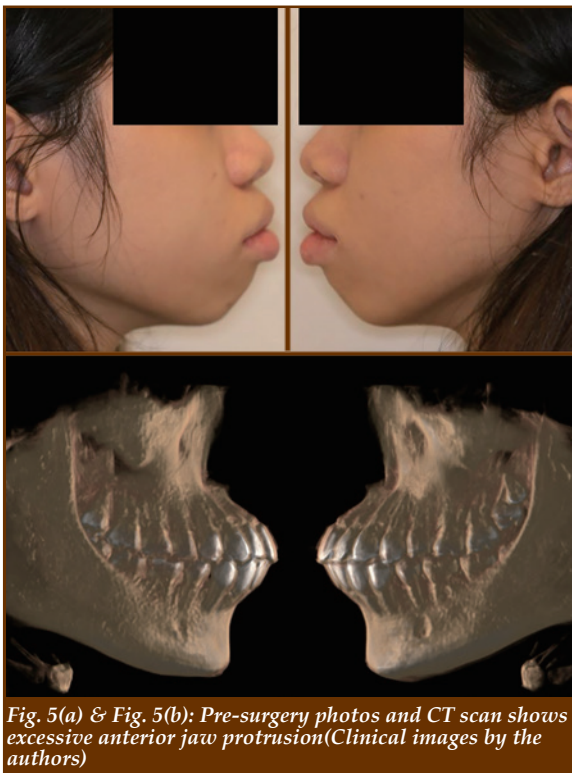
(a) & Fig. 5(b): Pre-surgery photos and CT scan shows excessive anterior jaw protrusion (Clinical images by the authors)
